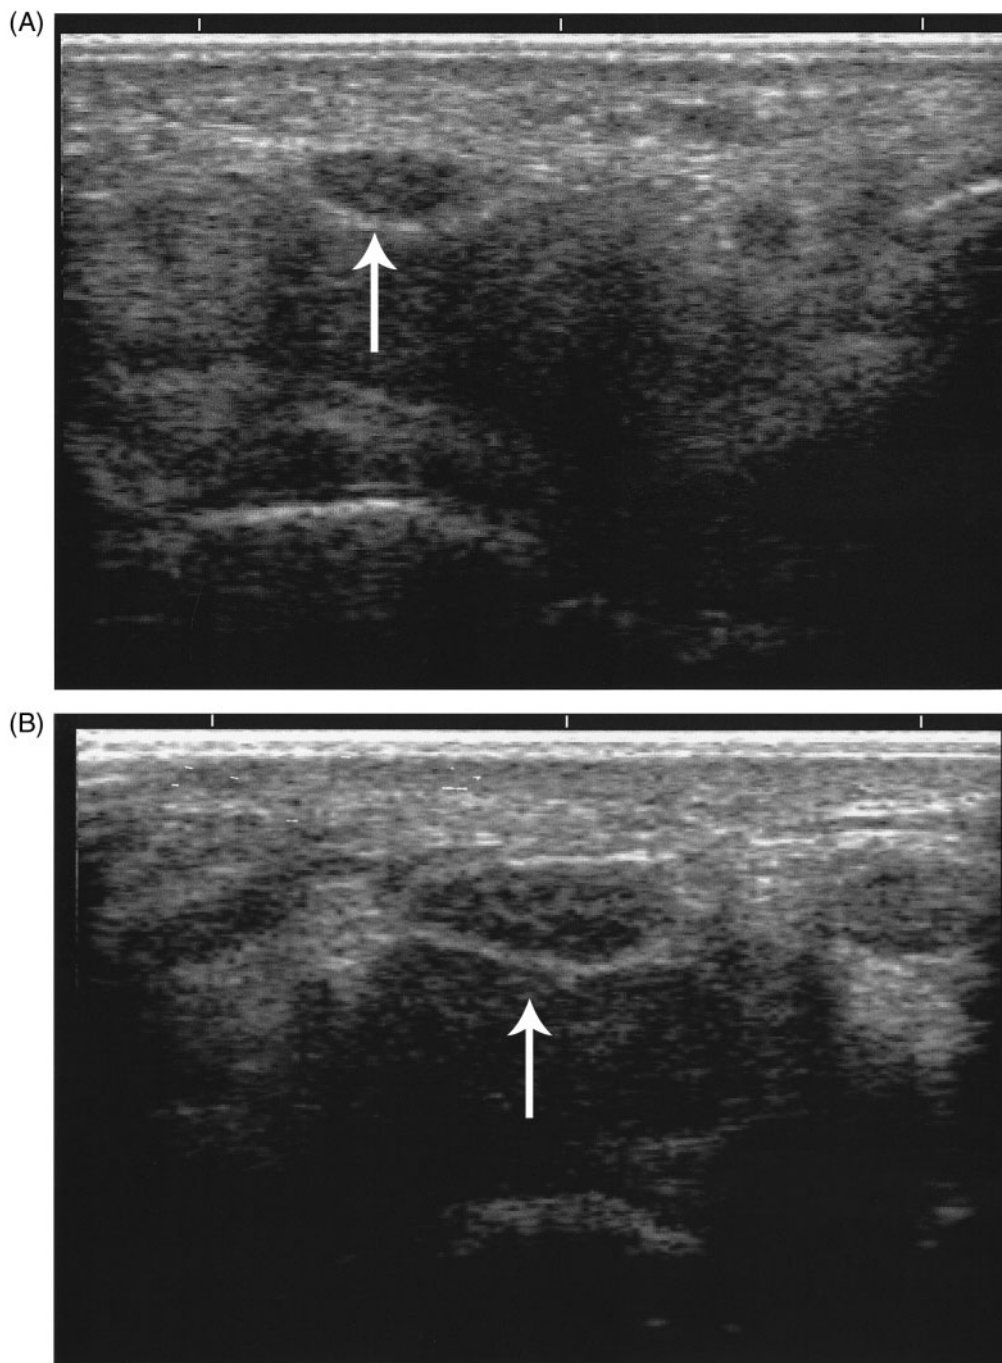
Ultrasonographic pictures of a normal median nerve from an RA patient without CTS symptoms (A) and a pathological median nerve from a patient with RA and CTS (B). The arrows indicate the median nerves.
